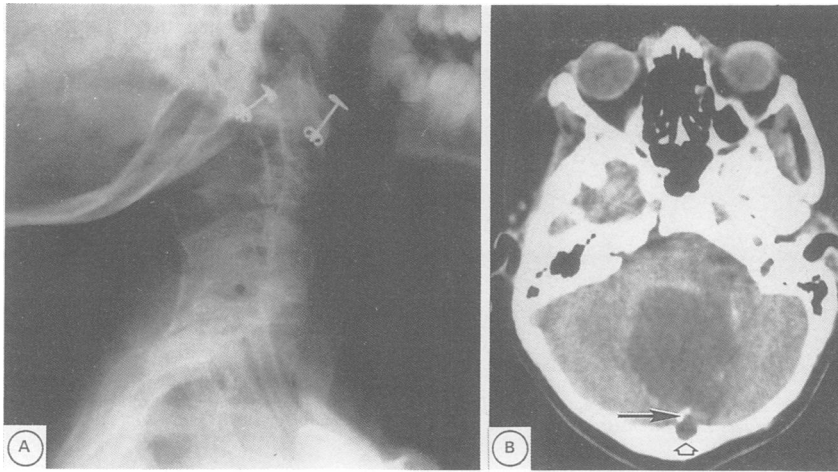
Figure a A lateral view of the cervical spine showing occipitalisation of the posterior arch of C1 with the anterior element apparently fused to C2. There is fusion of the posterior elements of C2 and C3 and of the anterior and posterior elements of C4, C5 and C6. Figure b CT scan showing a large midline hypodense mass lesion in the posterior fossa with peripheral flecks of calcification (solid arrow) and an associated midline defect in the occipital bone (open arrow).
